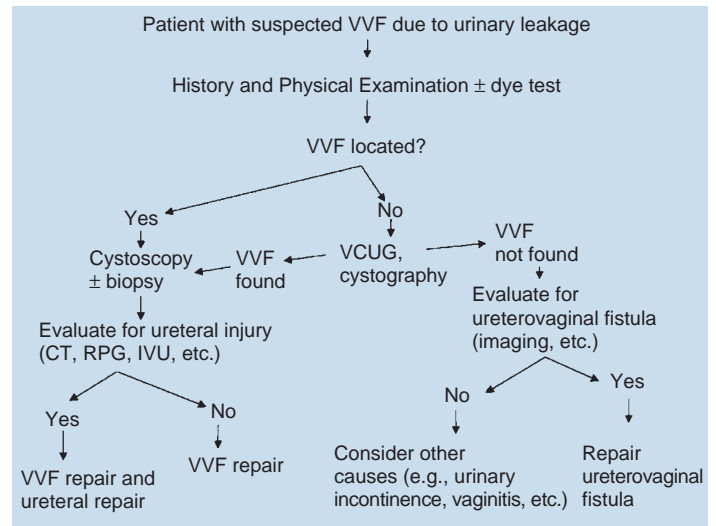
Algorithm for the diagnosis of vesicovaginal fistula (VVF). CT, computed tomography; IVU, intravenous urography; RPG, retrograde pyelography; VCUG, voiding cystourethrogram.
